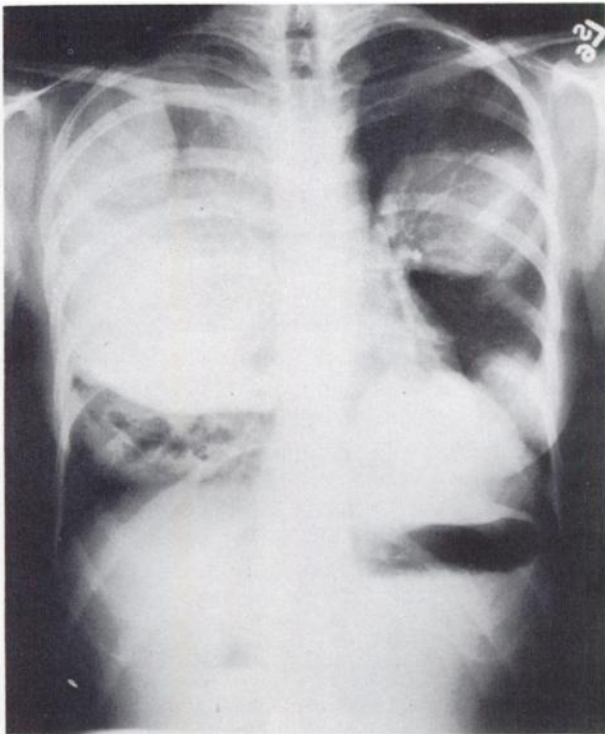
PA chest radiography of patient in September 1972. Metastatic masses occupy most of right hemithorax and half of left hemithorax. No calcification is seen.
